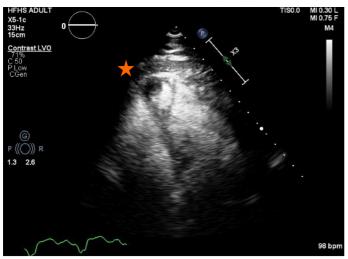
Transthoracic echocardiography highlighting the systemic right ventricle apical thrombus. A 1.3 cm × 1.3 cm well circumscribed mass with an echolucent center.
